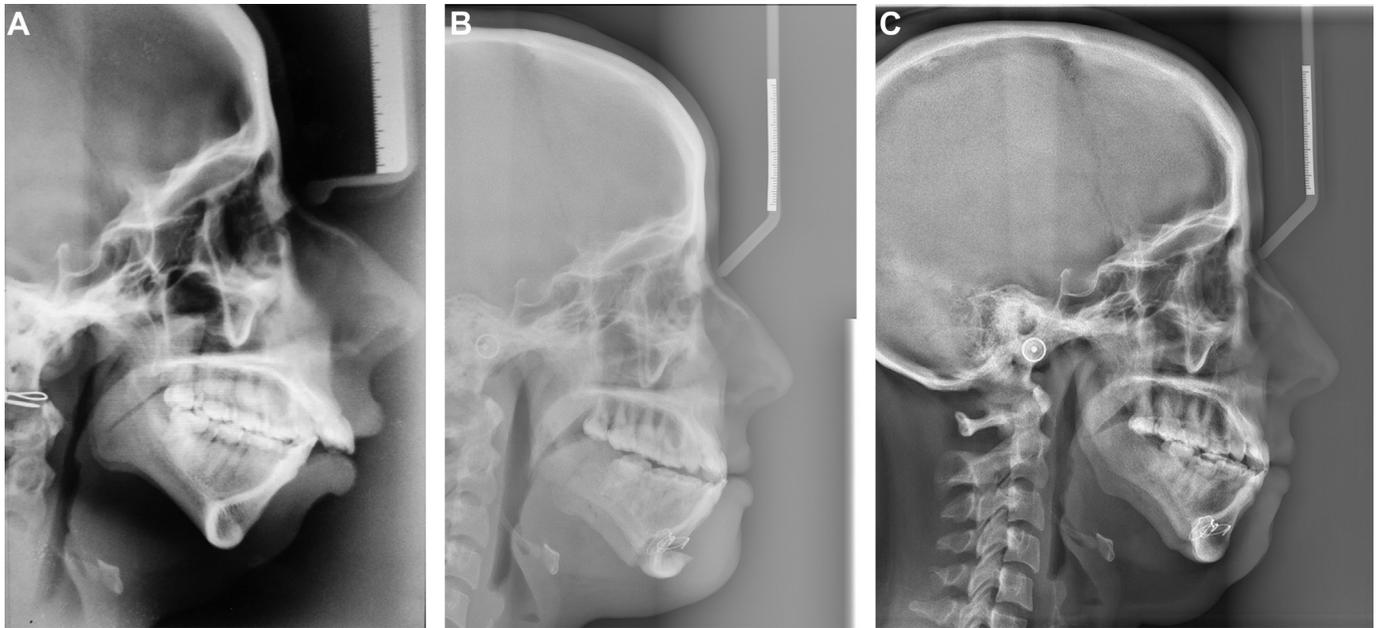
Lateral cephalometric X-rays of the patient in Fig. 2. (A) pre-distraction, (B) after the consolidation period and advancement genioplasty, and (C) at the longest follow-up period (8-years).
